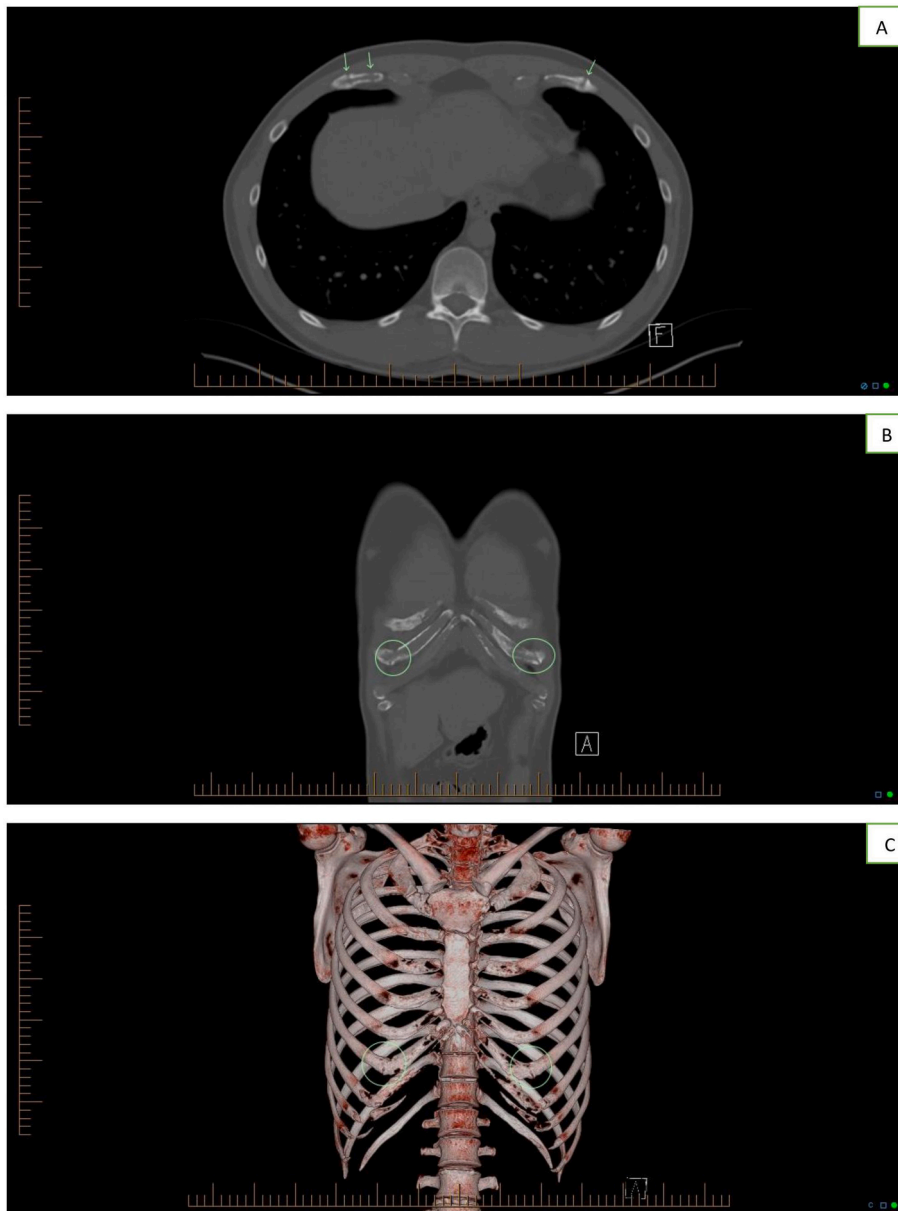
A. Axial image, B. Coronal image and C. 3D image of the CT chest demonstrate bilateral costal cartilage fractures, one transverse fracture at costal cartilage junction of the left sixth rib, two fractures at the costal cartilage junction and in the mid-cartilage of the right sixth rib (Straight arrows and circles).
